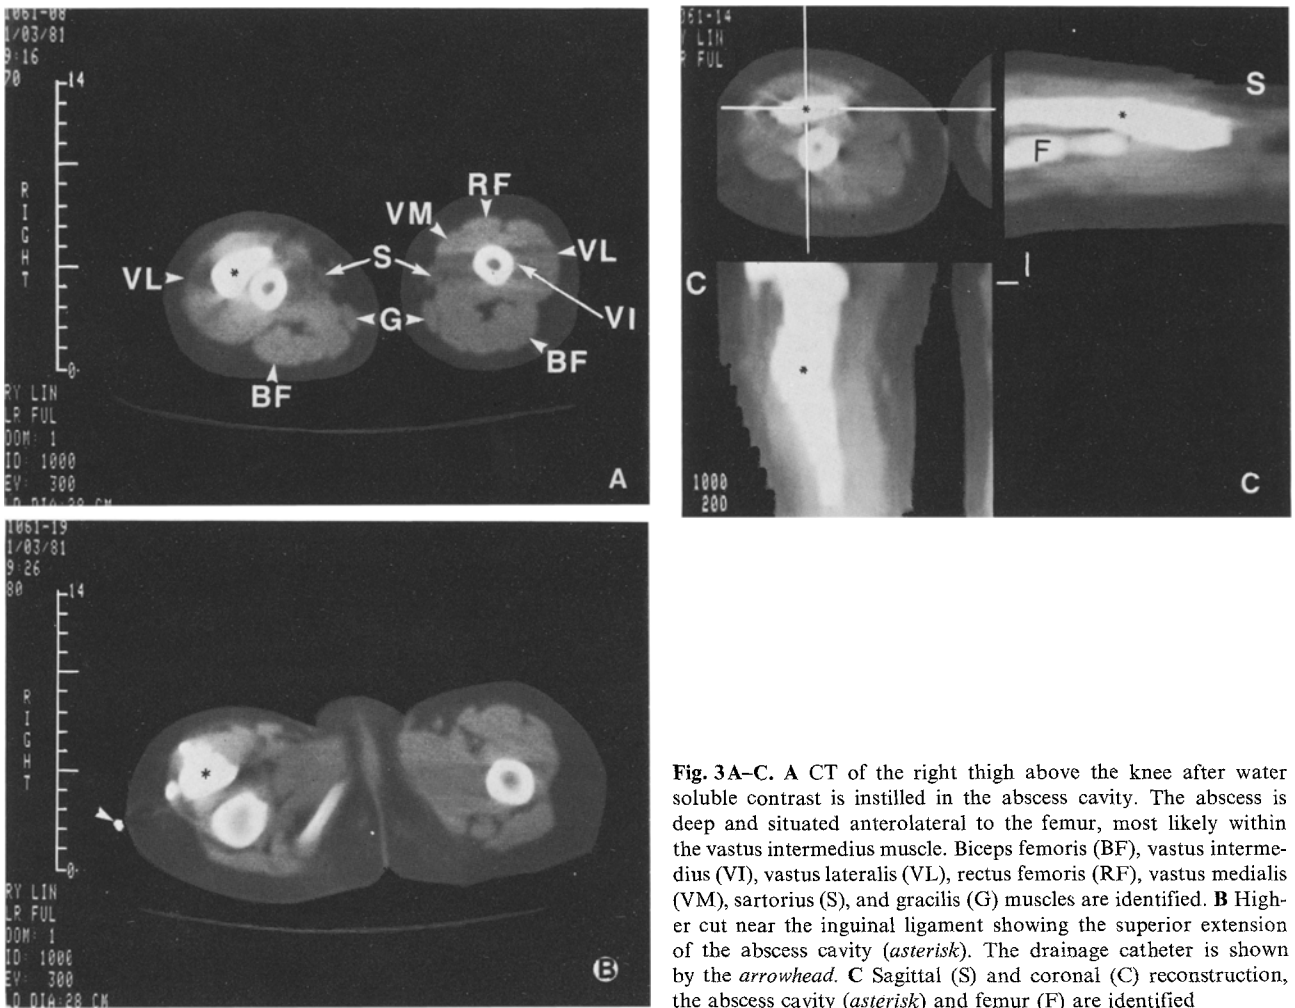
A CT of the right thigh above the knee after water soluble contrast is instilled in the abscess cavity. The abscess is deep and situated anterolateral to the femur, most likely within the vastus intermedius muscle. Biceps femoris (BF), vastus intermedius (VI), vastus lateralis (VL), rectus femoris (RF), vastus medialis (VM), sartorius (S), and gracilis (G) muscles are identified. B Higher cut near the inguinal ligament showing the superior extension of the abscess cavity (*asterisk*). The drainage catheter is shown by the *arrowhead*. C Sagittal (S) and coronal (C) reconstruction, the abscess cavity (*asterisk*) and femur (F) are identified
